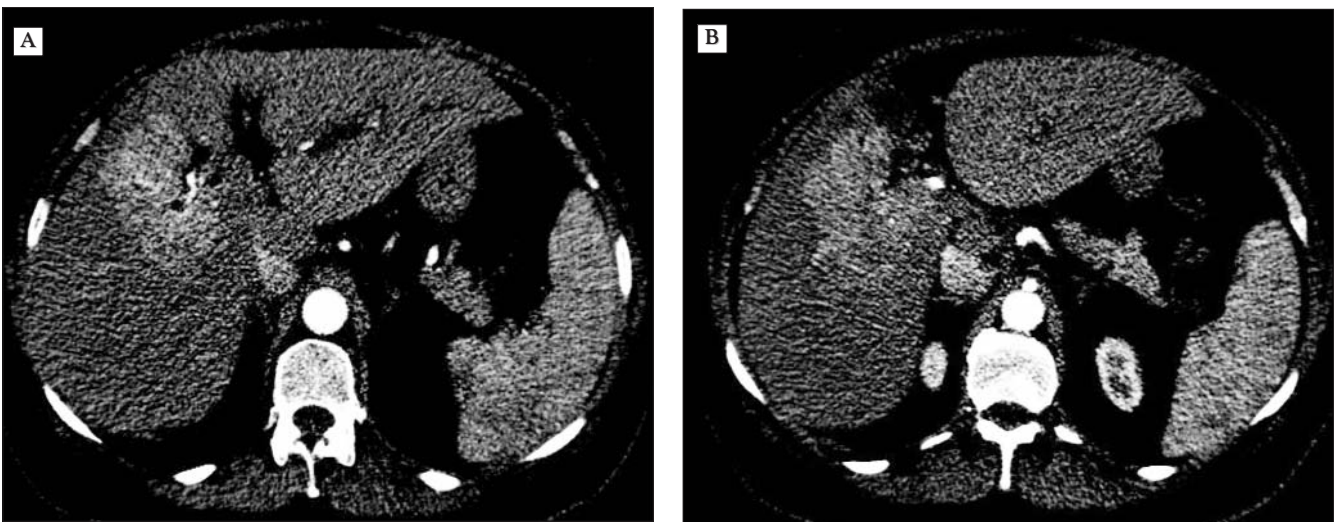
(A,B). Contrast-enhanced abdominal CT scan- 8/7 cm liver tumor involving segments 3, 4, 5, and 8, presenting arterial phase flash and late phase wash-out, with non-homogenous structure
